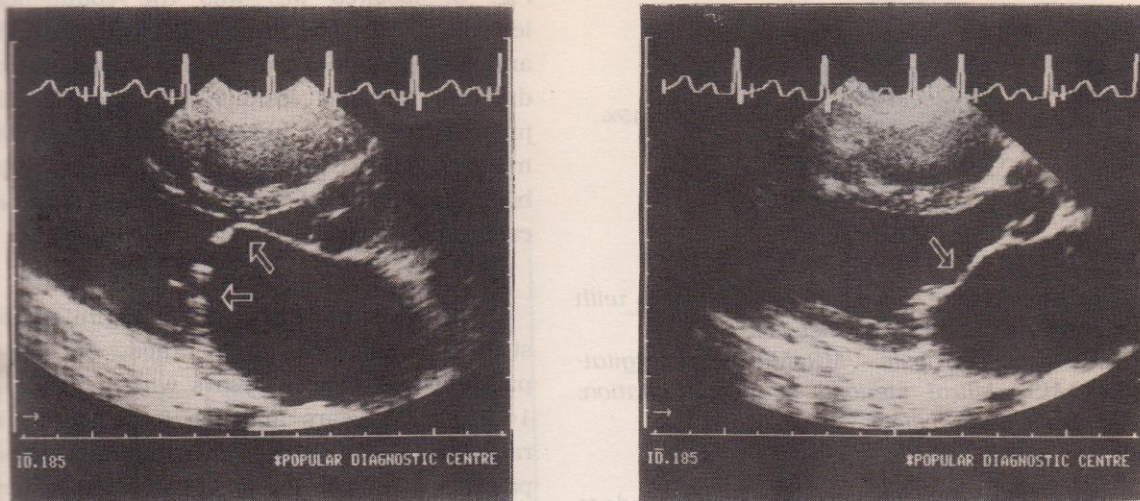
Long-axis two-dimensional echocardiograms in diastole (Left) and in systole (Right) from a patient with mitral stenosis. The diastolic frame shows severe doming of the AML while the systolic frame shows bulging (buckling) of the leaflet demonstrating its pliability.
